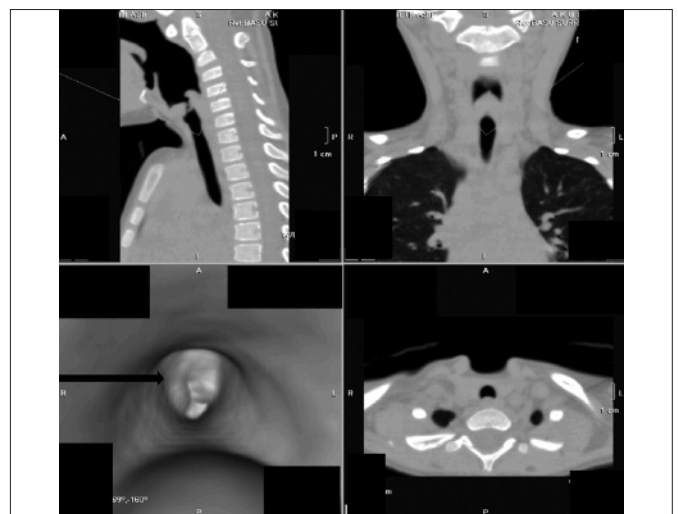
CT scan showing laryngeal stenosis due to presence of papilloma.
